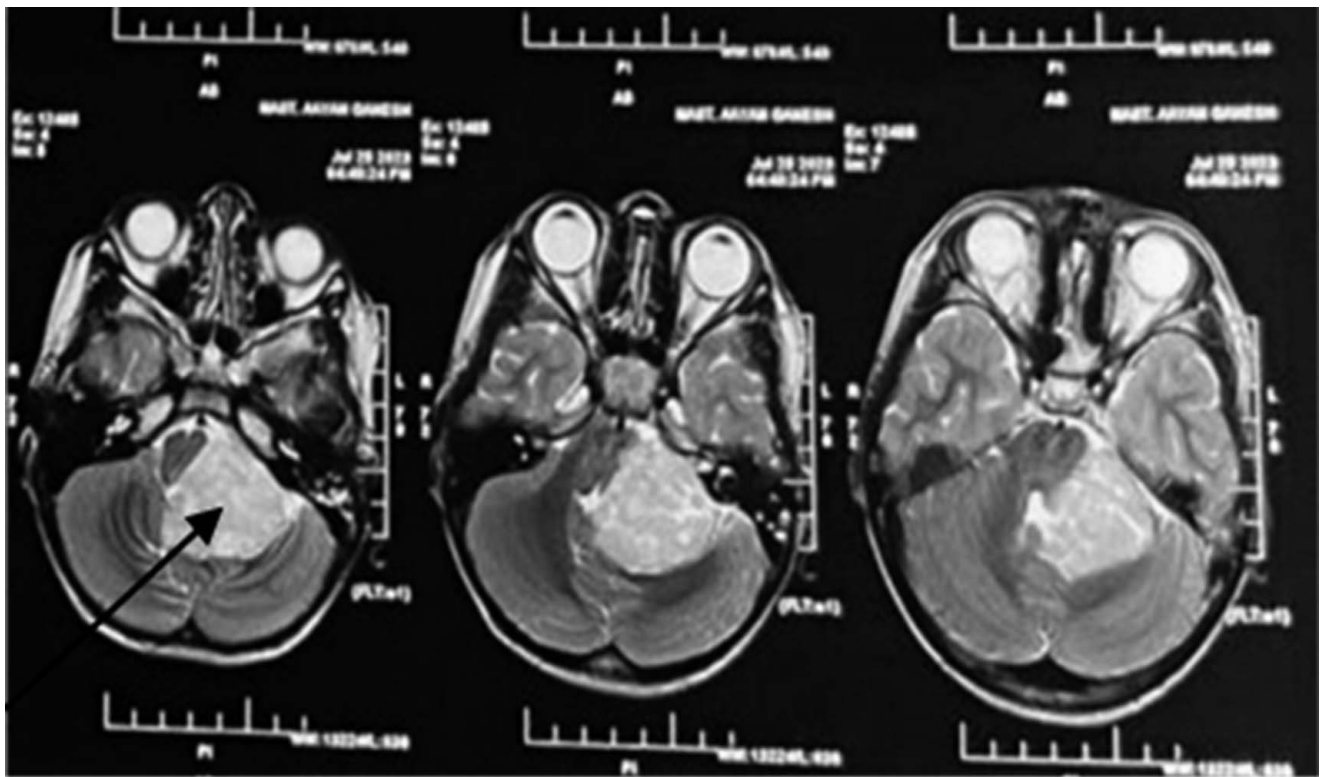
Hyperintense extra-axial space-occupying lesion (SOL) measuring around 43 × 39 mm in the left cerebellopontine angle region in T2 weighted MRI.
